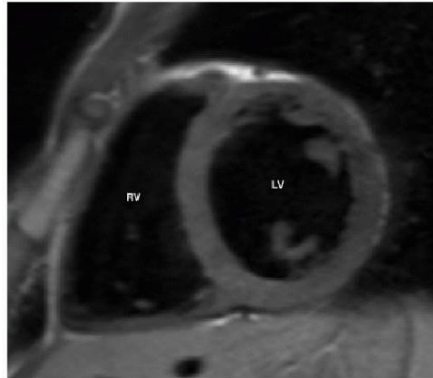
Black-blood T1-weighted short axis image through the mid aspect of the right and left ventricles (RV and LV). The grey appearance of the myocardium is clearly distinguishable from the dark intracavitary blood [44].
